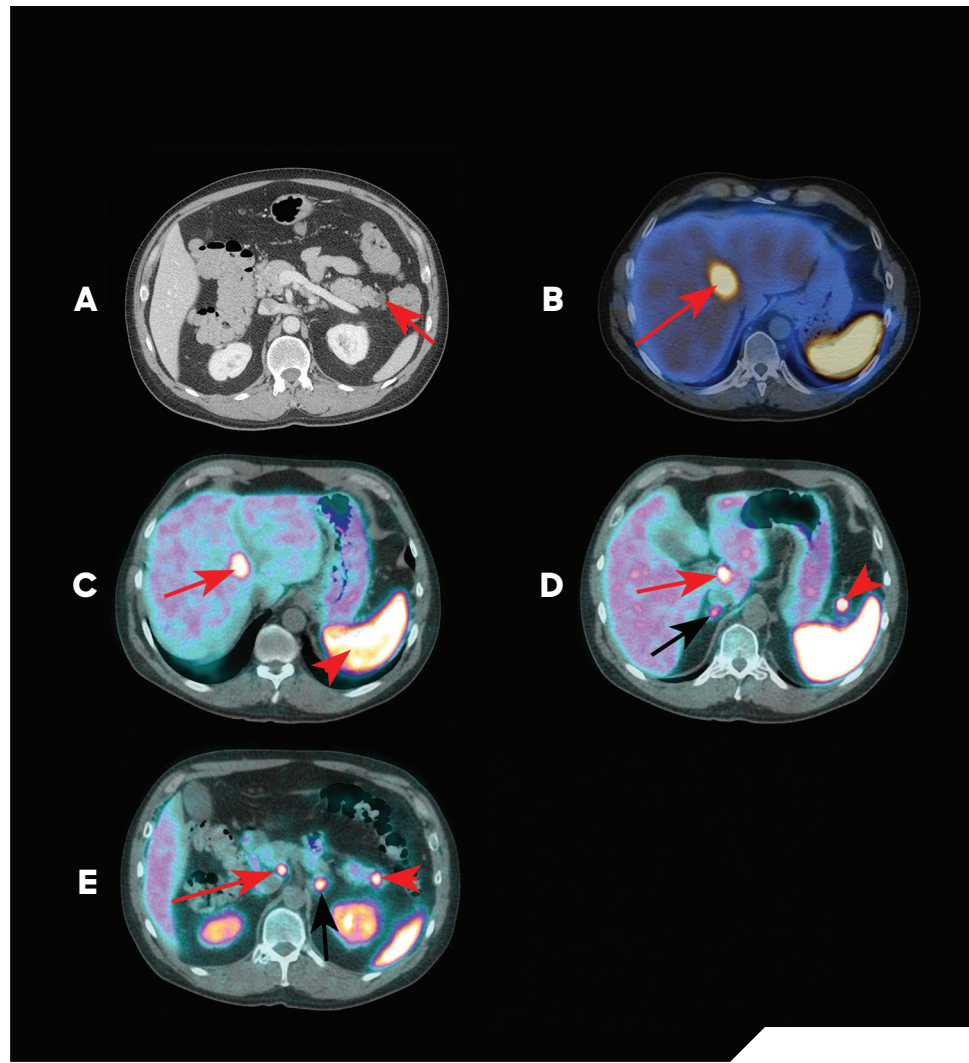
A patient had gastric ulcer disease related to an elevated gastrin level, believed to be due to a gastrinoma. A CT scan (Panel A) and MRI scan (not shown) showed a cystic lesion in the tail of the pancreas (arrow), with benign characteristics and no evidence of a gastrinoma or of metastases. A ^{111}In -pentetreotide scan (OctreoScan SPECT/CT; Panel B) demonstrated a single somatostatin-receptor-positive lesion in the right lobe of the liver (arrow), consistent with metastasis, but no primary tumor. Conversely, a ^{68}Ga -DOTATATE PET/CT scan (Panel C) showed the same right hepatic lobe metastasis, but showed several additional lesions, including a second hepatic metastasis in the caudate lobe (Panel D, red arrow). Additional, very small, somatostatin-receptor-positive metastases were demonstrated in subcentimeter lymph nodes in the splenic hilum (Panel D, arrowhead) and the periceliac region (Panel E, red arrow). Finally, ^{68}Ga -DOTATATE imaging also revealed focal tracer uptake consistent with the primary gastrinoma in the tail of the pancreas (Panel E, arrowhead), involving the medial aspect of the cystic lesion that had appeared benign on CT and MRI. Note also that Ga-DOTATATE demonstrates intense and variable uptake in a number of normal structures (e.g., kidneys, spleen [Panel C, arrowhead], and adrenal glands [Panels D and E, black arrow]) and benign lesions, which necessitates skilled and meticulous interpretation of such studies.
